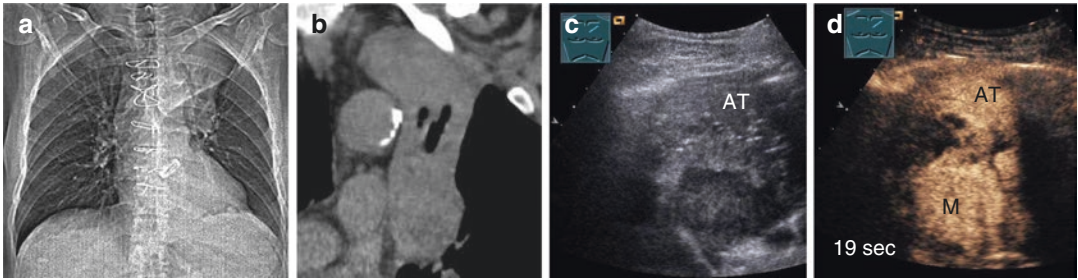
Patient with lung cancer shown on X-ray examination (a) and on CT scan (b); B-mode imaging presents a homogeneous lung consolidation unable to
